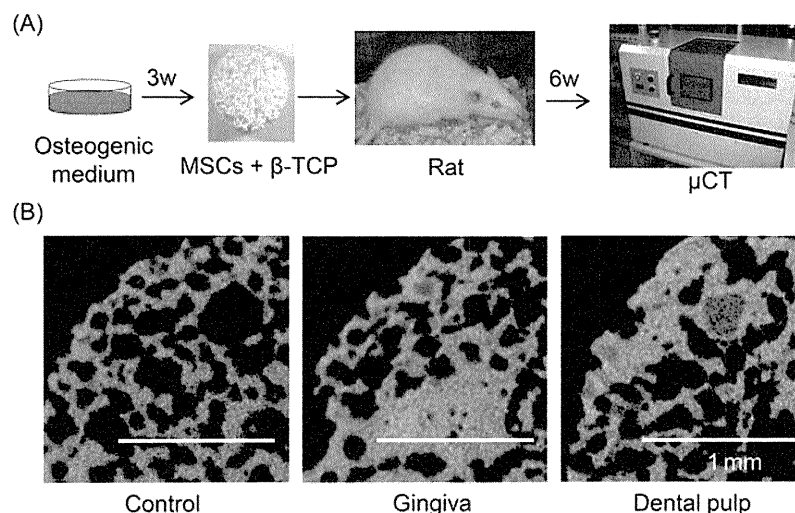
In vivo osteogenic potential of gingival and dental pulp cells after 6 weeks of implantation. (A) Protocol. (B) Microcomputed tomography images of implants.
